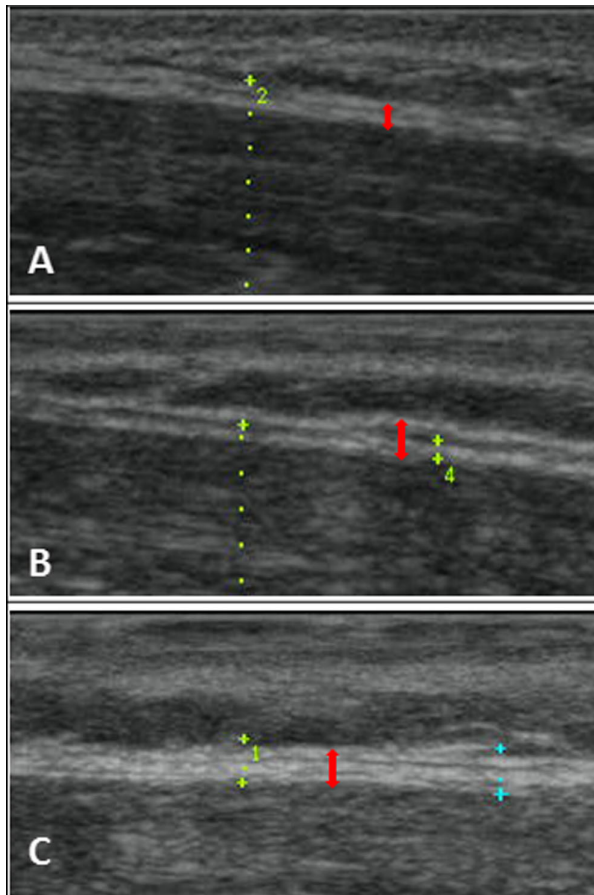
Ultrasonography of the deep fascia of the neck over the sternocleidomastoid muscle. The deep fascia is highlighted with a red arrow. a Normal fascia, the two fibrous layers (white layers) and the loose connective tissue (in black) in the middle are visible. b Densification of the same fascia: the loose connective tissue is increased, the fibrous layers are normal. The total thickness of the deep fascia is increased. c Fibrosis of the same fascia. The fibrous component is increased as is the total thickness of the fascia (in this patient it measures 1.8 mm)
